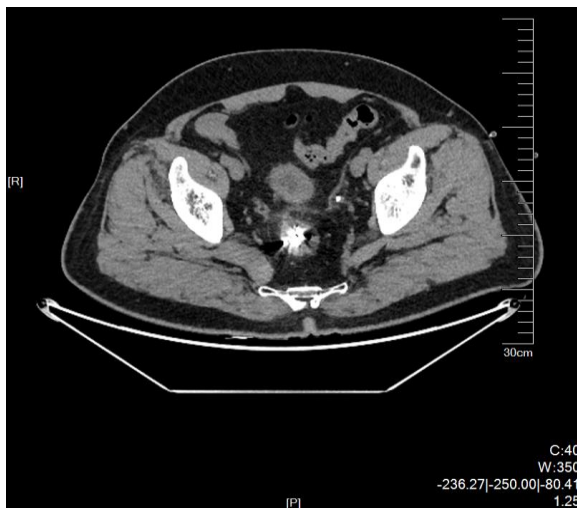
CT scan shows a nodular high-density shadow (titanium clips) in the rectal cavity, without fluid or gas accumulation around the rectum.
